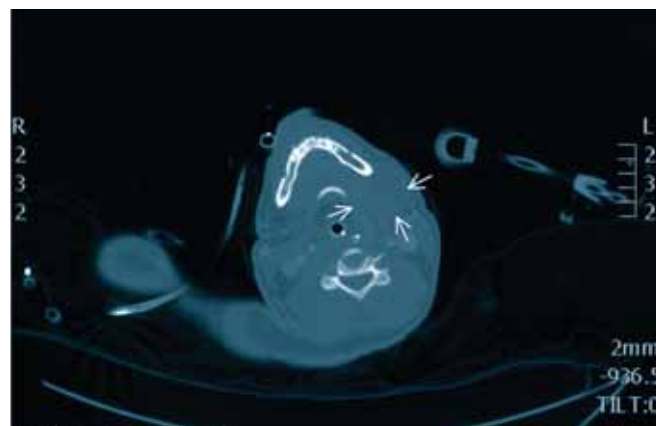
(above): A: Axial CT scan showing large left parapharyngeal space abscess (arrows). B (left): Axial CT showing large collection in the pericardial sac with a catheter drain inserted into the pericardial cavity for drainage (dashed arrows), pleural effusion (arrow heads) and areas of consolidation (solid arrow).
